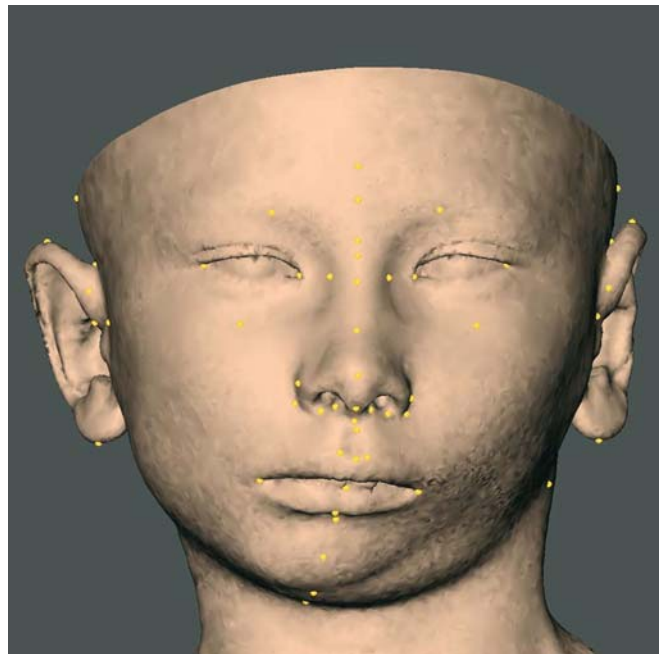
Pre-operative 3-D CT soft tissue surface representation with set-up of 3-D cephalometric soft tissue landmarks. Frontal view. (3-D CT, patient B.R.)
